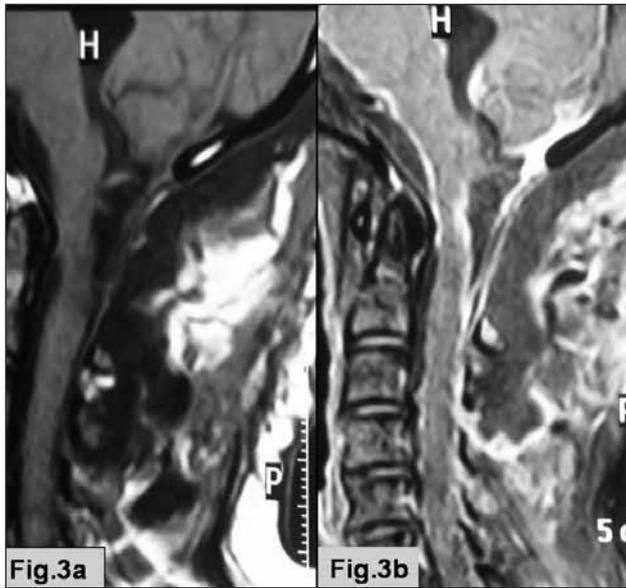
Postoperative sagittal T1W (Fig. 3a) and post-contrast sagittal MR image (Fig.3b) showing no residual lesion.
